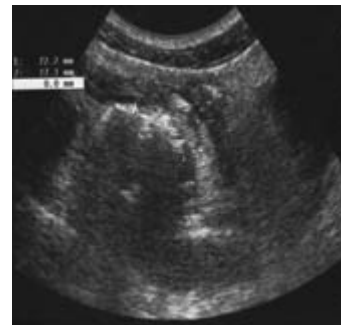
Ultrasonography showing a fluid collection in favor of appendiceal abscess
